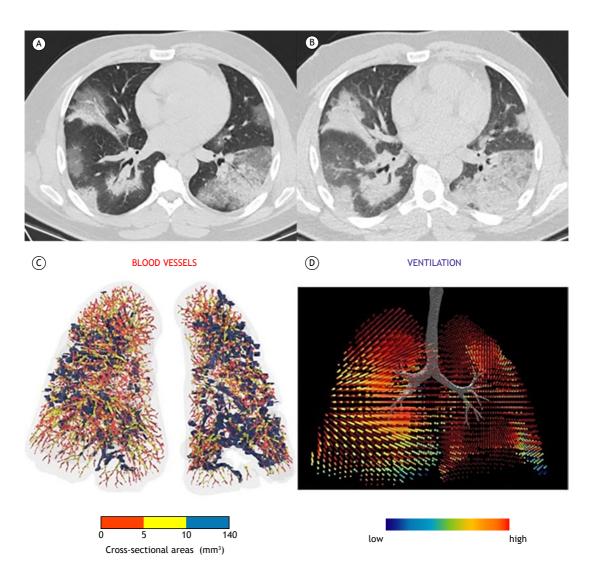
Typical appearance of COVID-19 (classic pattern)—50-74% parenchymal involvement. HRCT axial images obtained during inspiratory (in A) and expiratory (in B) acquisitions with no evidence of air trapping. In C, three-dimensional visual representation of blood vessels colored according to their size (red, yellow, and blue corresponding to small, mid-sized, and large vessels, respectively). Cross-sectional areas < 5 mm³ are sparse throughout the lung, indicating severe diffuse vasoconstriction even in areas without consolidation. In the ventilation map (in D), most areas of the lung are colored red, representing a normal expansion of lobar volumes between inspiration and expiration, even in areas where there is severe vasoconstriction of small blood vessels.
